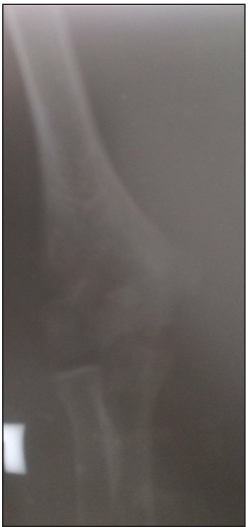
X-ray of the right elbow (frontal view)
